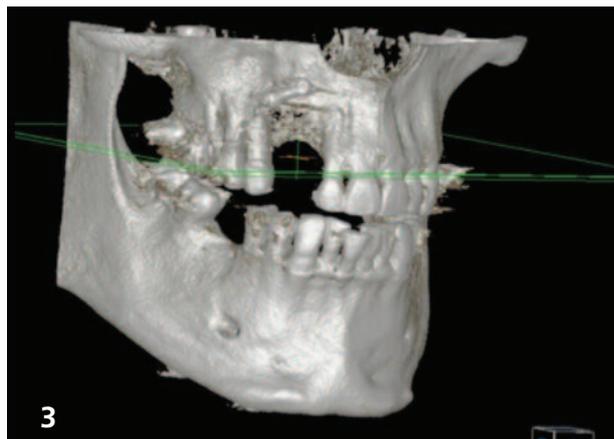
3D reconstruction of CBCT.
